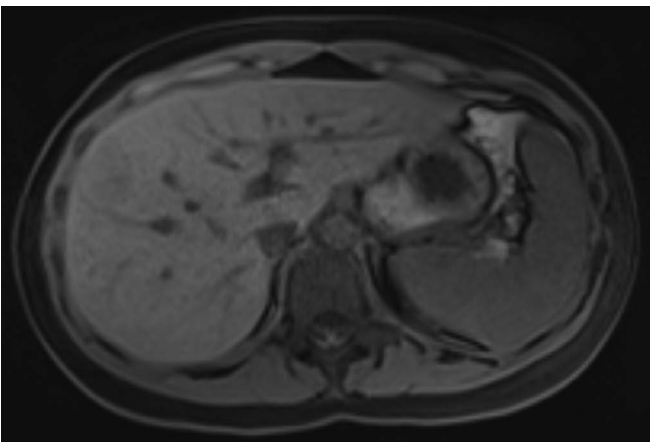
Liver. MRI. T1 weighted. Fat suppression.
